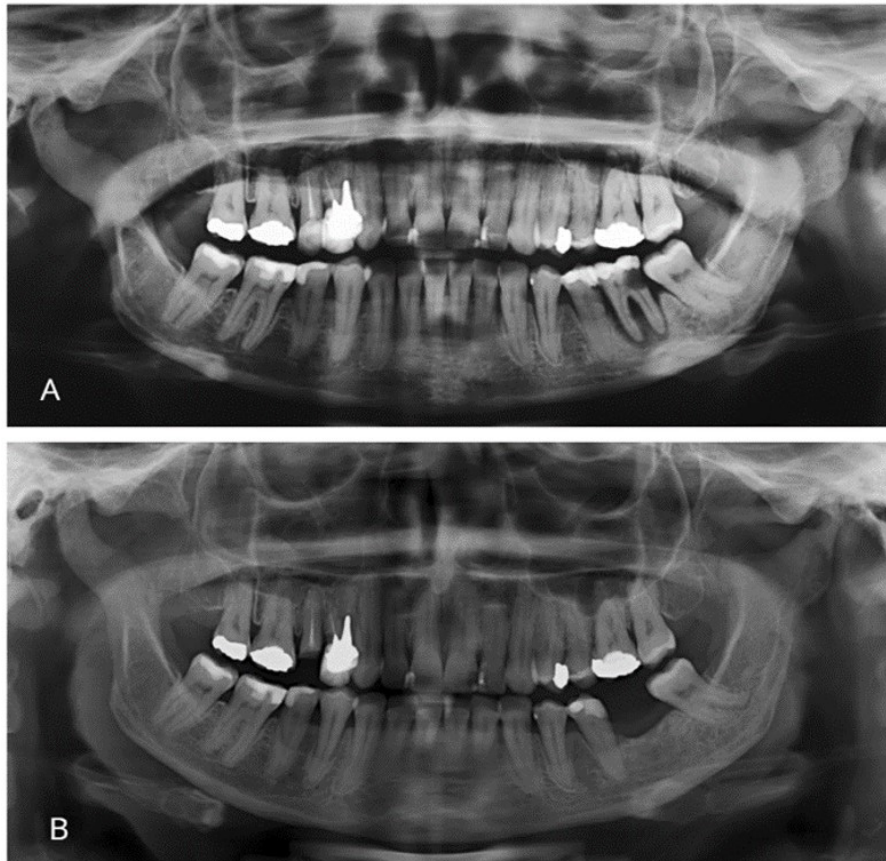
A: Panoramic radiograph of the patient at the start of treatment, in 2016. B: New panoramic radiograph requested in 2018.
